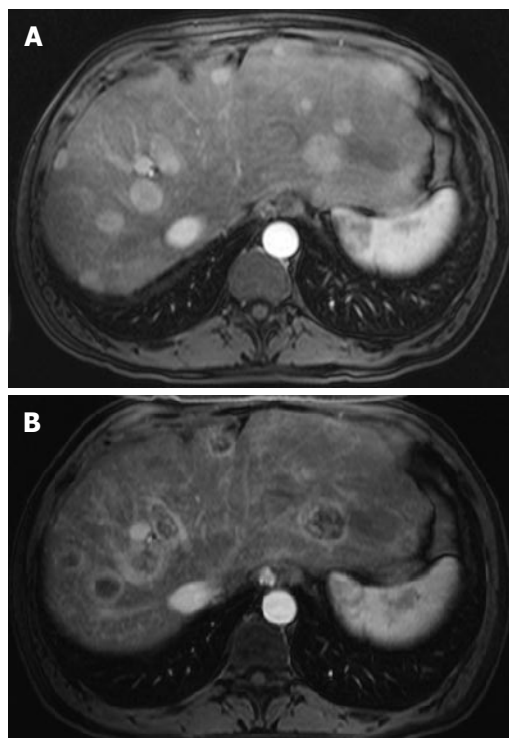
Pre-treatment magnetic resonance imaging of the liver demonstrating multifocal recurrent tumor within liver allograft (A) and paired post-treatment image showing central necrosis of lesions after treatment with yttrium-90 microspheres (B).
